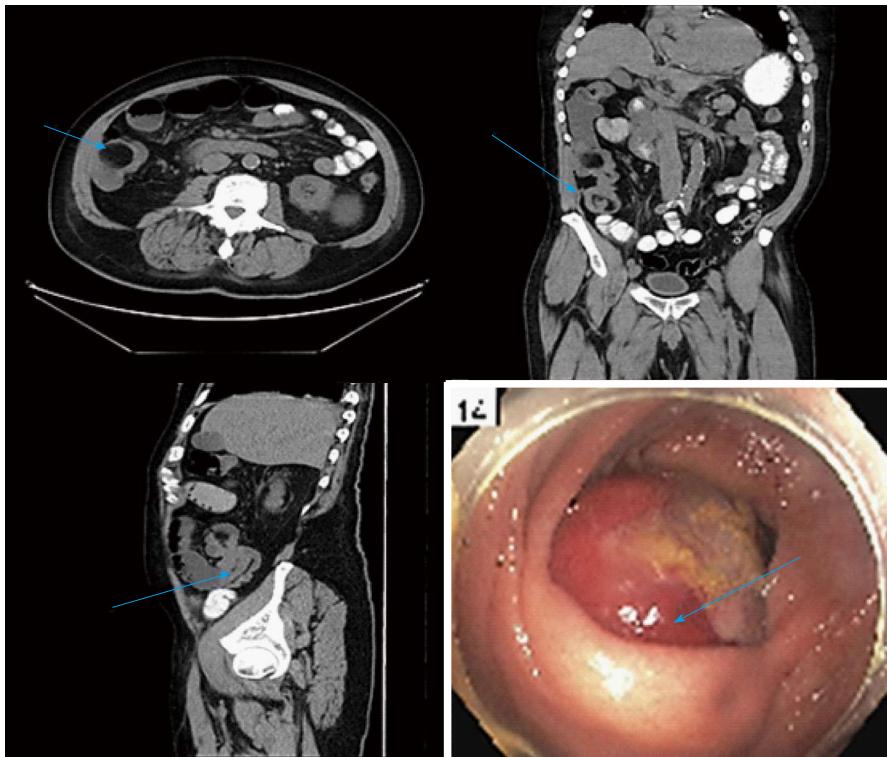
Ileocecal intussusception. Computed tomography scans (axial, sagittal, coronal) shows the mass intussusception in the cecum. Colonoscopy confirms the mass protruding through the ileocecal valve.
